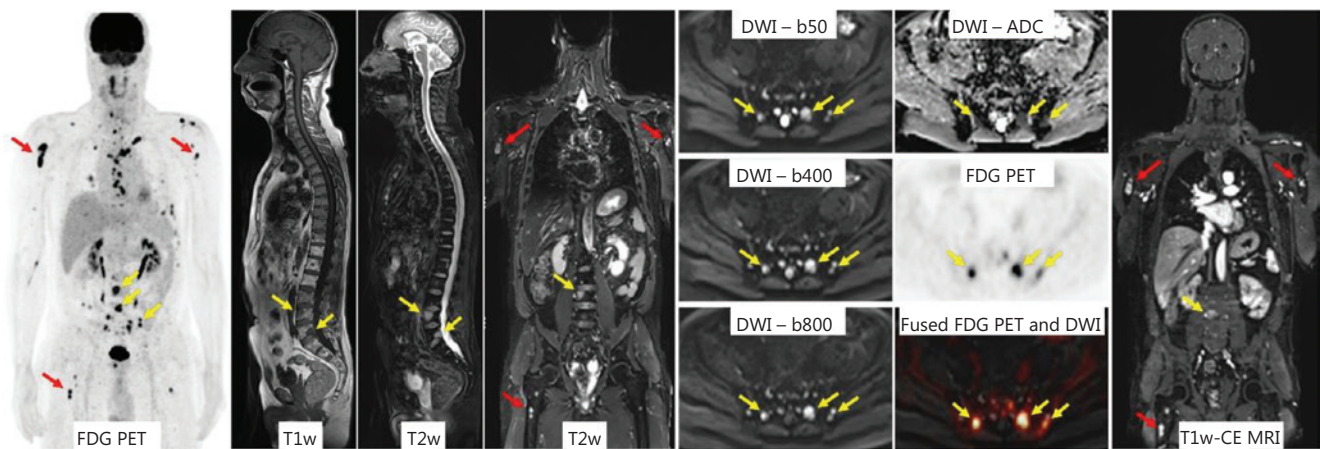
PET-MRI in a patient with multiple myeloma. Focal bone lesions are visible in the axial skeleton (yellow arrows) and in the proximal upper and lower extremities (red arrows) in ^{18}F -fluorodeoxyglucose (FDG) PET, in DWI images at different b-values ($b = 50$, $b = 400$, $b = 800$), in the ADC map, and in fat saturated contrast-enhanced T1w images (T1w-CE MRI). The combined structural, metabolic, and MR functional (DWI) information enables multiparametric, multifunctional characterization of the multifocal disease activity. Adapted from Ref.²⁰⁰ (CC BY 4.0 license).
